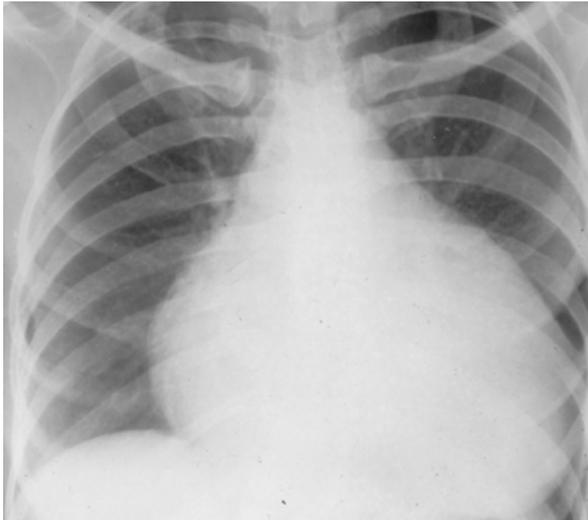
Cardiomegaly on a chest x-ray.
